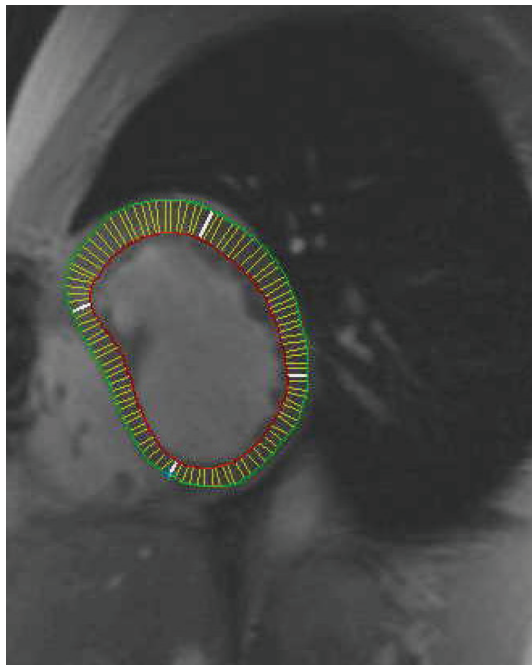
Magnetic resonance image showing a slice through the middle of the morphologically right ventricle in a patient with congenitally corrected transposition. The endocardial (red) and epicardial (green) contours are shown, along with 100 centerline (yellow) cords of the systemic ventricle. ccTGA: congenitally corrected transposition.
